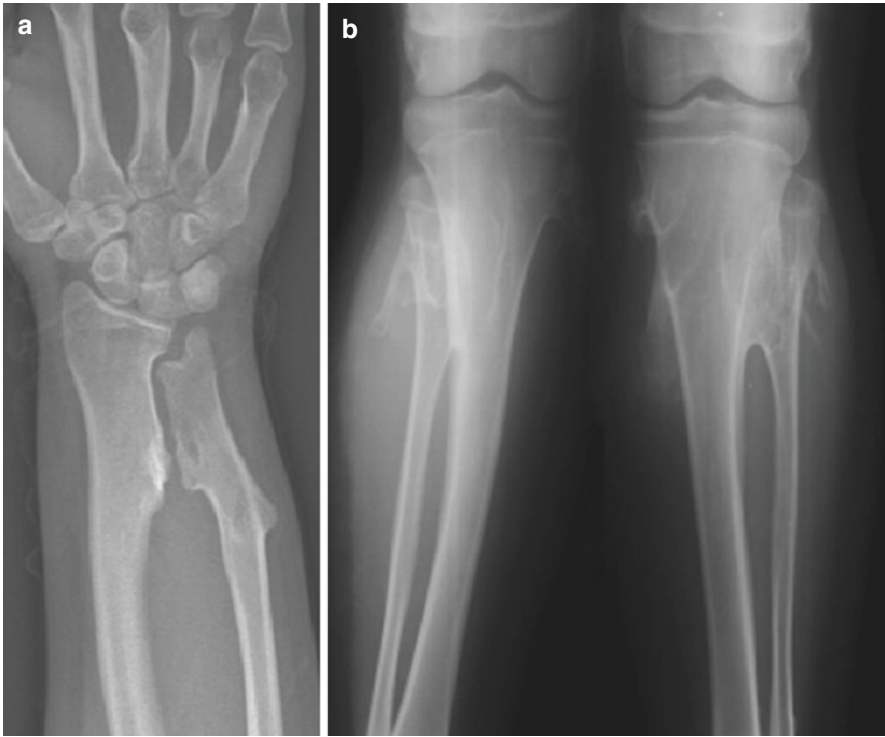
Upper and lower extremity osteochondromas in an MHE patient: (a) AP X-ray of right-hand demonstrating lesions on distal ulna and radius. (b) AP X-ray of lower extremities demonstrating lesions in bilateral proximal tibiae. Valgus deformity of the right tibia can be appreciated. [Courtesy of Prof. Alpaslan Şenköylü]
